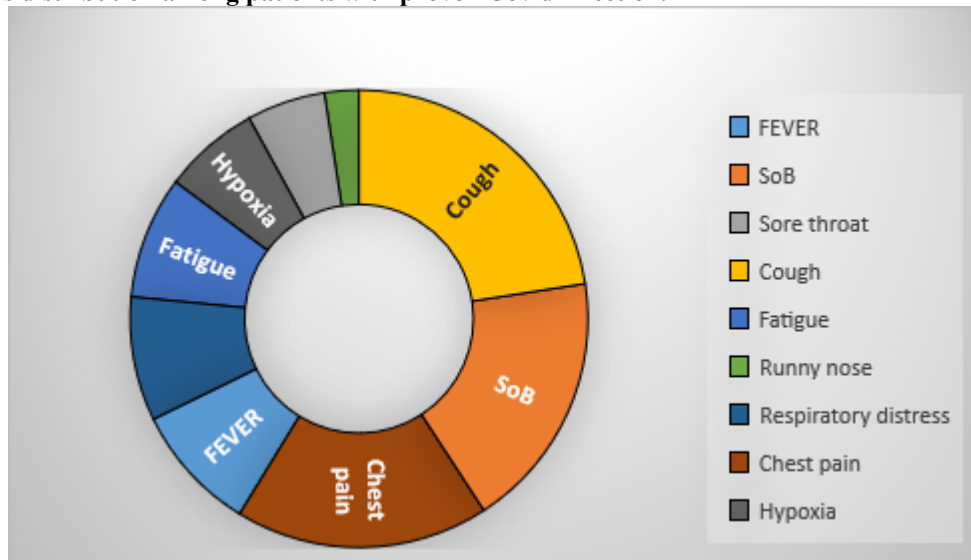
Common clinical findings among COVID-19 patients who underwent CT scan
